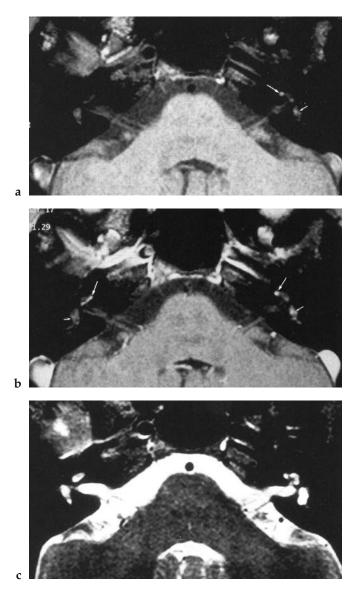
a Axial projection, T1-weighted, two-dimensional fast low angle shot (2D-FLASH), no contrast medium. Cogan's syndrome, subacute stage. Signs of subacute haemorrhages are the signal increases in the vestibule (*short arrow*) and in the cochlea (*long arrow*); b axial projection, T1-weighted 2D-FLASH after administration of Gd-DTPA in the same patient. Clear enhancement by contrast medium in the area of the haemorrhage, namely in the cochlea (*long arrow*) and in the vestibule (*short arrow*); c axial projection, T2-weighted turbo-spin-echo imaging, no contrast medium, in a patient with Cogan's syndrome. The canals cannot be delimited; this is a sign of obliteration from scarring.
